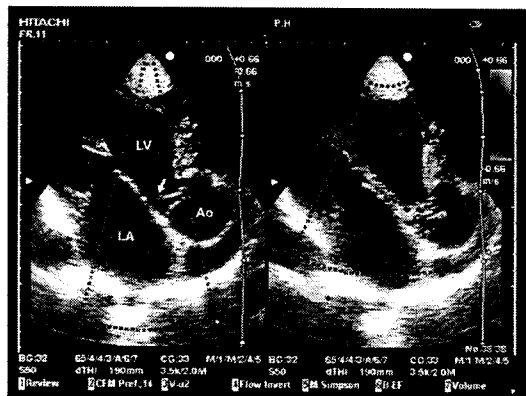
The ruptured right aortic cusp (arrow) in apical long axis view and a moderately eccentric aortic regurgitation in color Doppler echocardiography is seen. LV, left ventricle; LA, left atrium; Ao, aort
